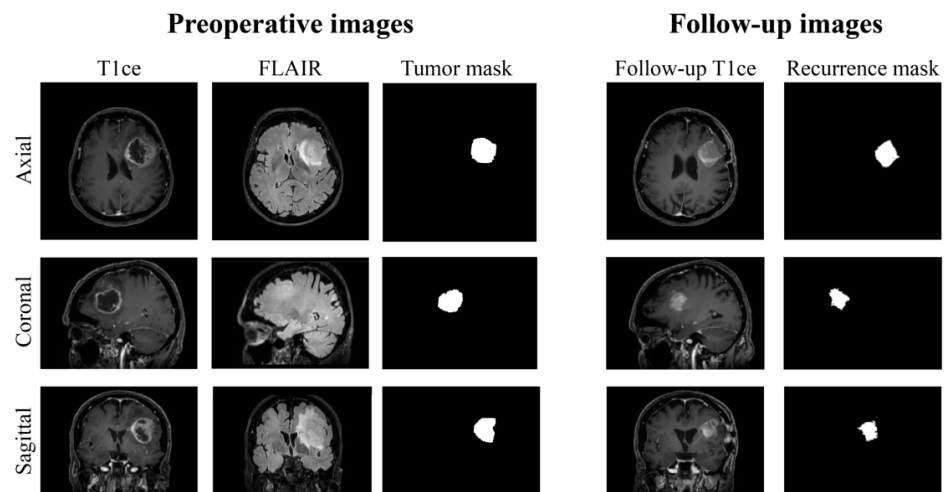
Example of preoperative and follow-up MRI after preprocessing and co-registration. From left to right: preoperative T1ce image, FLAIR image, tumor mask, follow-up T1ce image, and manually annotated recurrence mask. Rows show axial, coronal, and sagittal views.
